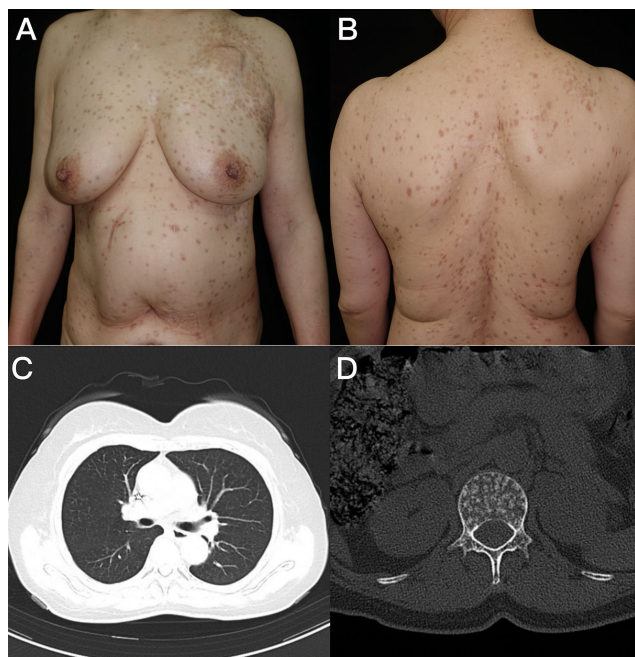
Post-treatment presentation of the patient: (A, B) Post-treatment skin presentation showed remission of xanthogranuloma. (C) Chest CT showed clear pulmonary fields. (D) Spinal CT showed multiple hypodense lesions.
